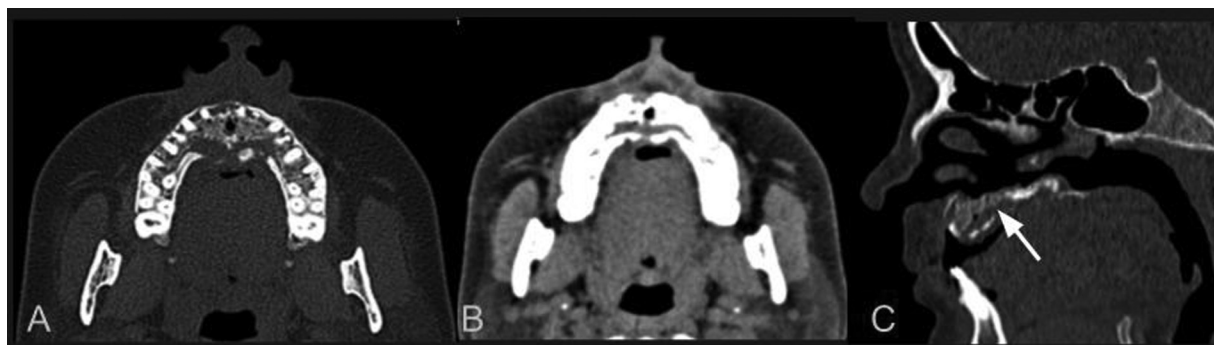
Osteonecrosis secondary to viral infection in the maxilla. A 40-year-old patient with a history of viral illness presented with loosening of the upper teeth 1 month later and developed oral discharge subsequently. Computed tomography (CT) shows well-margined areas of osteolysis in the maxillary alveolar process including the anterior hard palate right involving the outer and inner cortices of the bone. Separated pieces of bone within osteolysis are in keeping with bony sequestrum (white arrow). No abnormal periosteal reaction—consistent with osteonecrosis.
